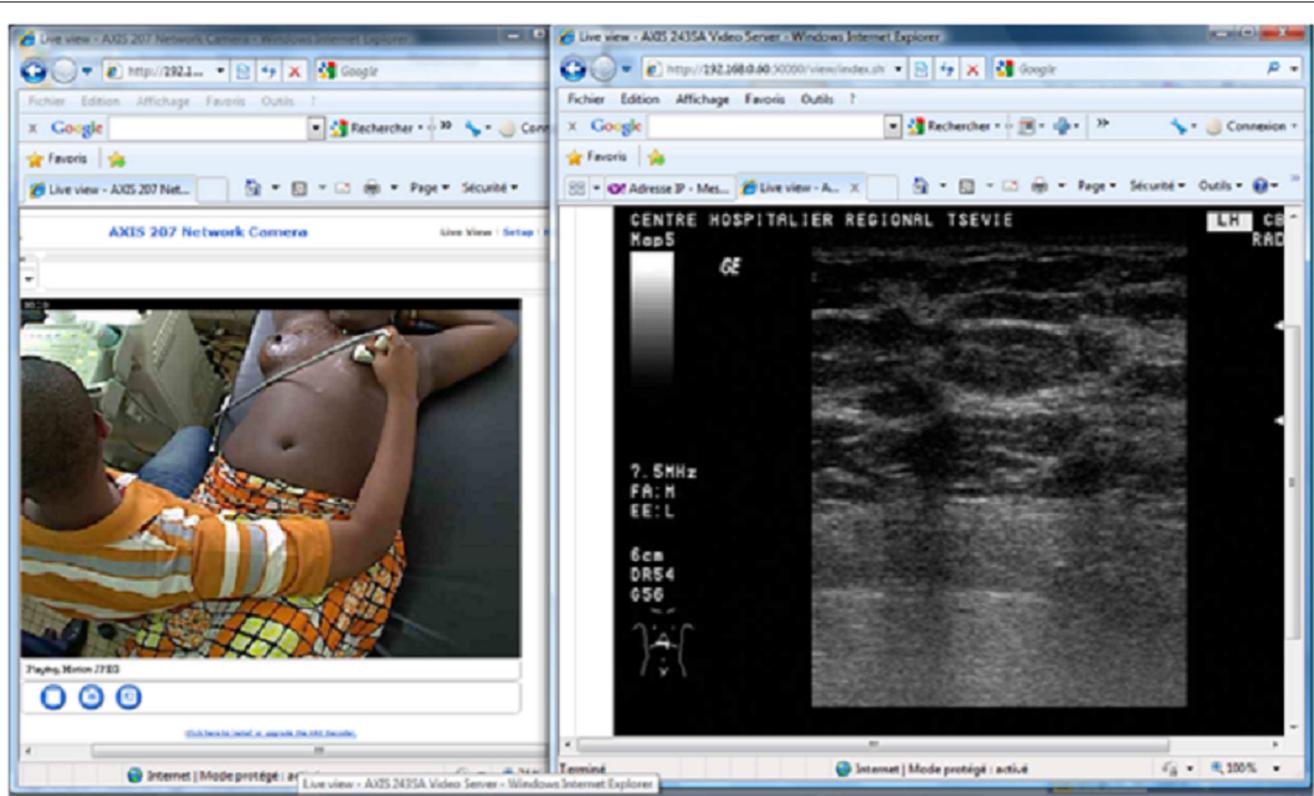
Screen capture at the expert center during mammary ultrasound with Axis technology.
